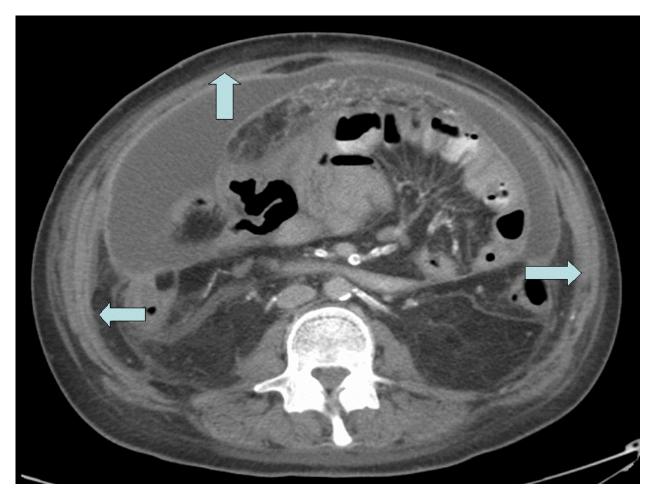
CT image of the abdomen shows dilated small bowel loops surrounded by thickened fibrous peritoneum.
